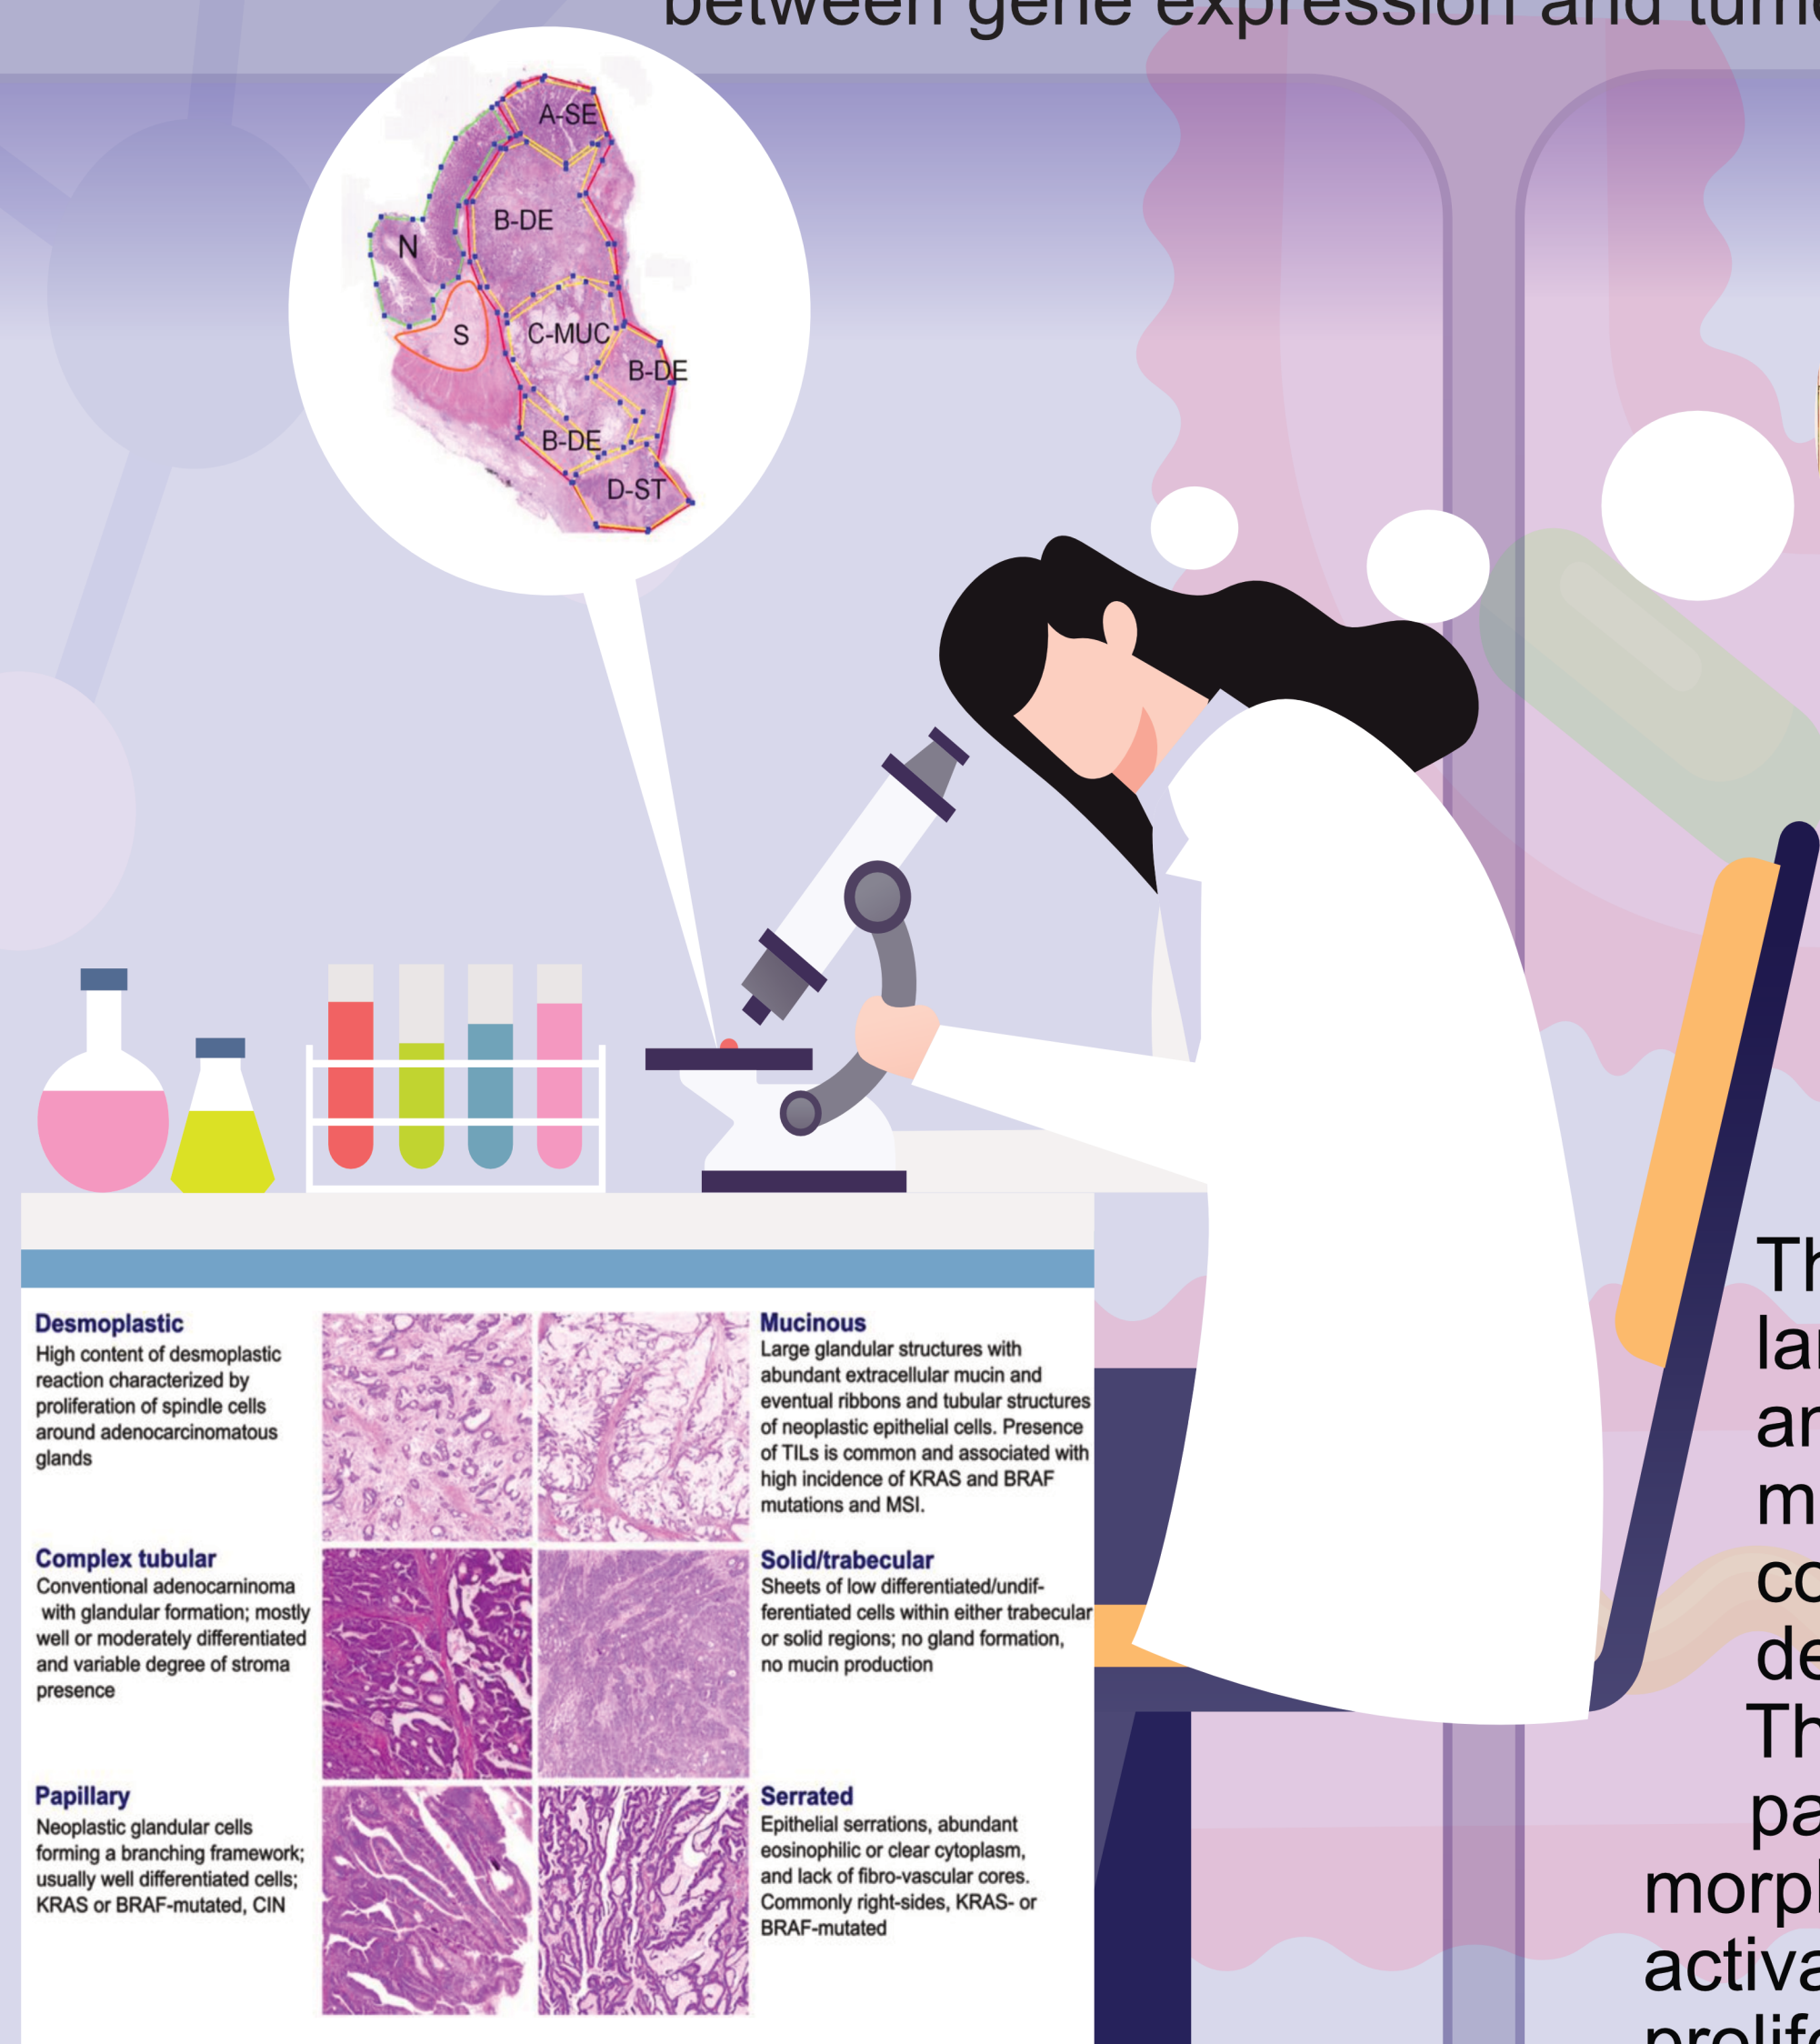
The six CRC morphological patterns of interest (morphotypes). UP: example of an original annotation used for macrodissection and RNA extraction. DOWN: examples of morphotypes – complex tubular (CT), desmoplastic (DE), mucinous (MU), papillary (PP), serrated (SE), and solid/trabecular (TB).
